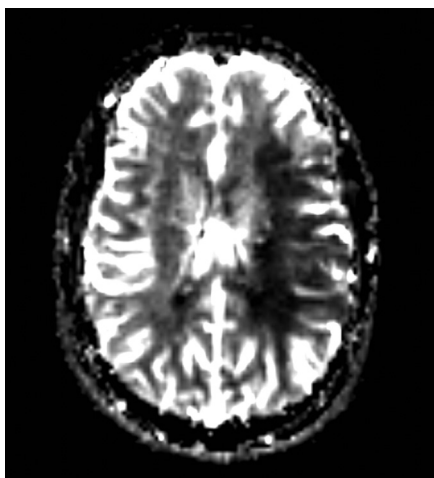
■ Perfusion deficit. Magnetic resonance imaging perfusion study shows hypoperfusion in the territory of the left middle cerebral artery after thromboembolic obstruction at the M1 segment.
